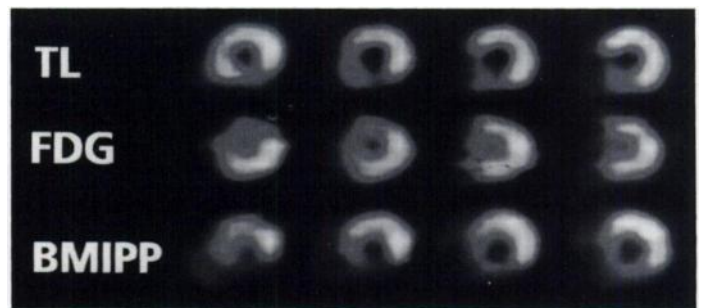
Patient (73 yr-old man) with a 14-yr-old inferior myocardial infarction. The short-axis slices show a FDG/Tl mismatch but a BMIPP/Tl match in the inferior wall.
